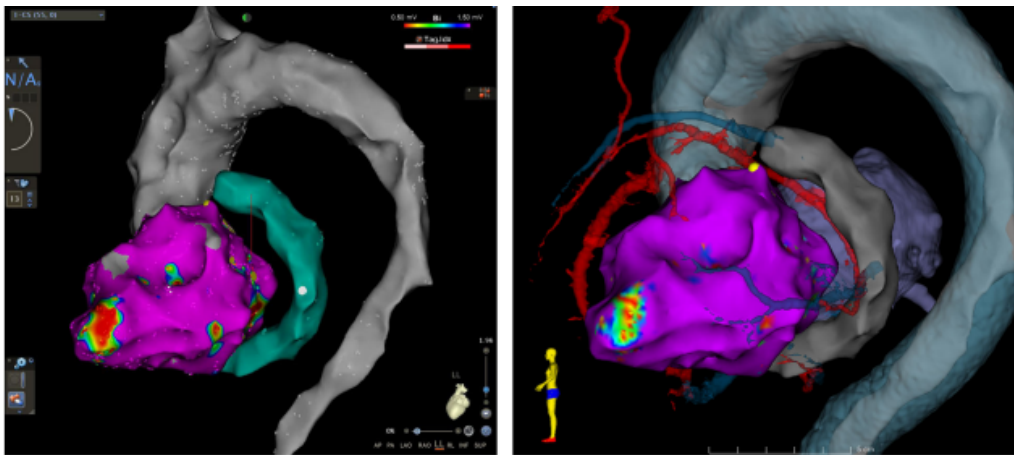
EAM 3D-3D integration. On the left, it is possible to depict the EAM and on the right, the corresponding view after import and registration to the cardiac CT in 3D Slicer as proposed by S. Hohmann et al. [156].
